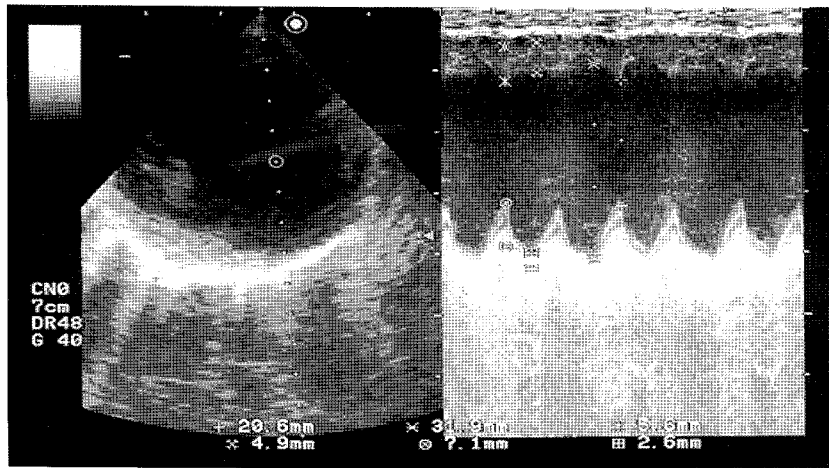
The 2D and M-mode echocardiography taken from right parasternal short axis view of papillary muscle level showed increased LV dimension in systole and diastole.
